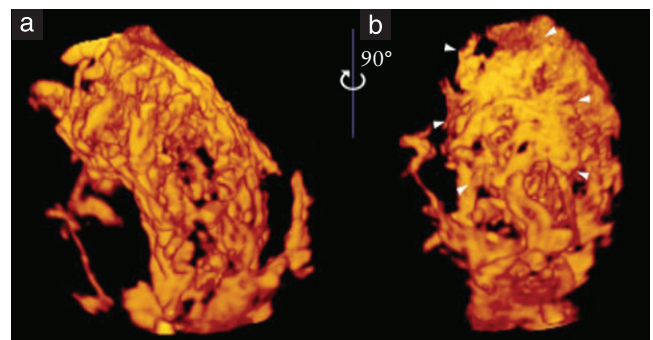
Intraplacental hypervascularity on three-dimensional power Doppler: (a) lateral view; (b) basal view. Reproduced from Shih *et al.*²⁵ with permission.
